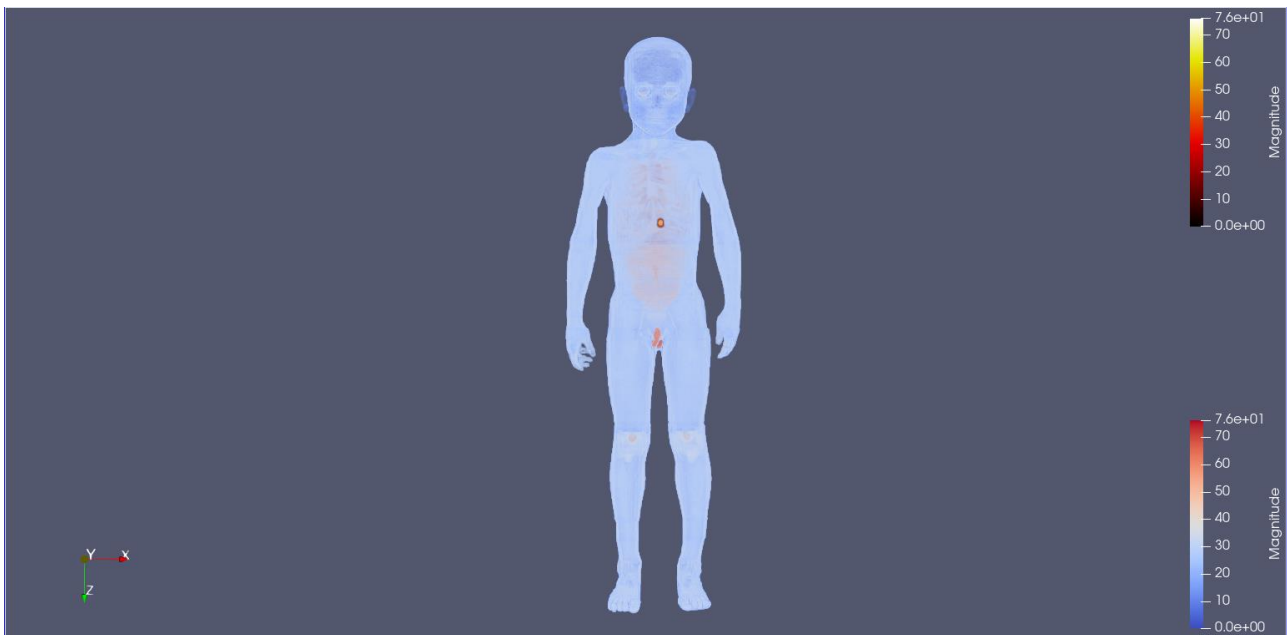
Focus: SAR representation with colour range between [0 - 0.01], body colour range between [0 – 250] in x-ray pre-set using “shade” option and generated field magnitude colour range between [0 – 76] in body-black radiation pre-set
